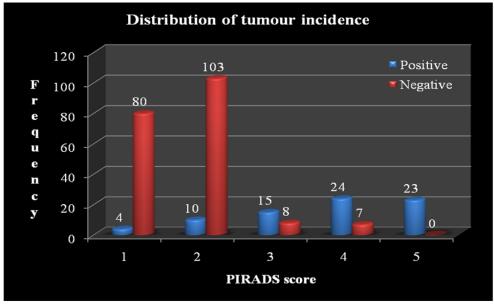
Distribution of tumour incidence chart - DWI PIRADS score
